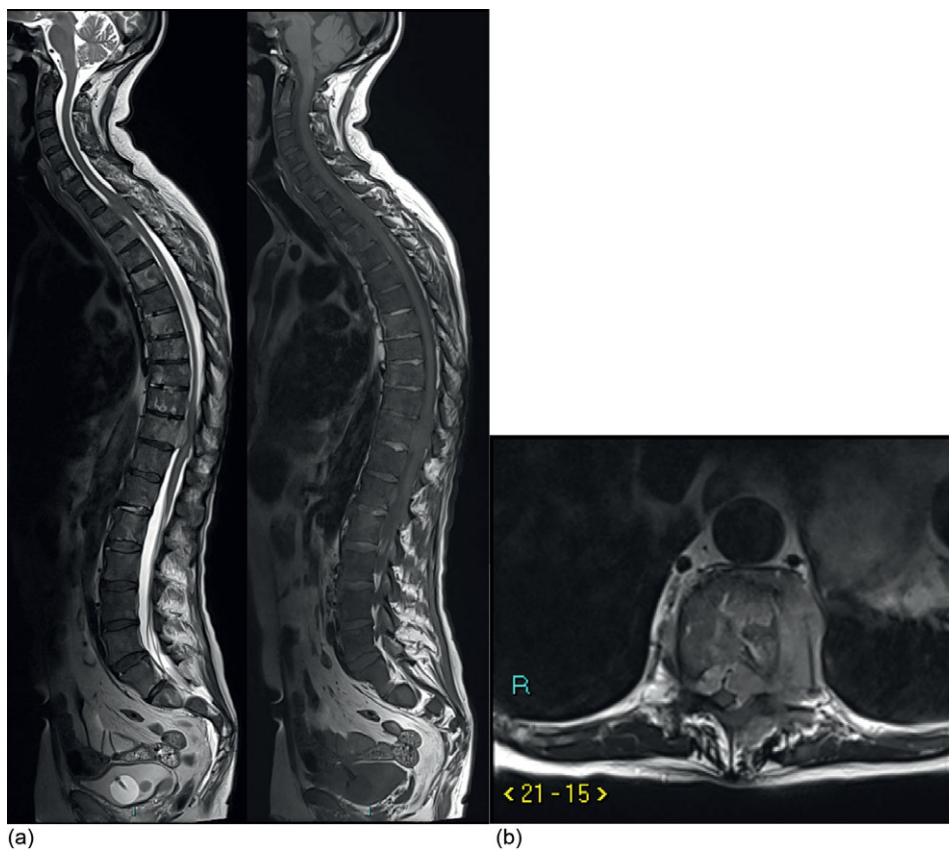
(a) T1 and (b) T2 sagittal whole spine MRI images and (c) T2 axial at T1
